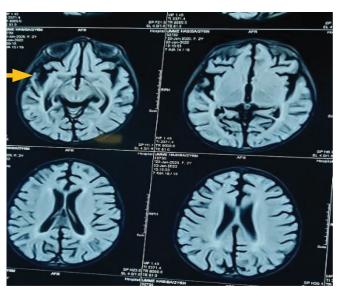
MRI of Brain flair image showing generalized cortical atrophy
